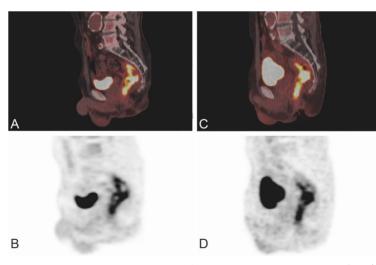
Response monitoring recurrent rectal cancer. Representative images of PET/CT (A, C) and PET (B, D) one week into treatment (A, B) and during the third cycle of treatment (C, D).
